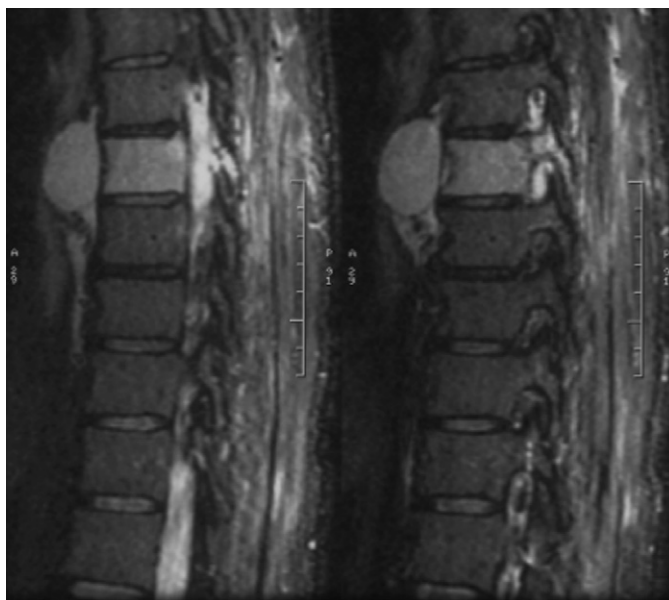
Case 2: 57-year-old male who had liposarcoma resected from flank 9 years ago. Acutely presented out of state with neurologic deficit. Laminectomy performed; presented for oncologic resection. Sagittal T2-weighted MRI demonstrated T7 liposarcoma with paravertebral involvement.
